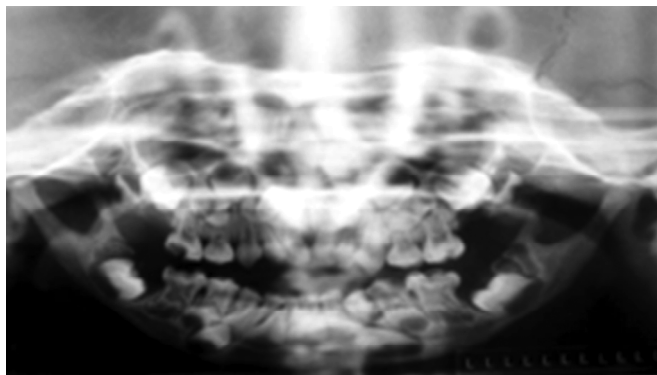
Panoramic radiography revealing obtuse mandible angle, acute caries and malpositioned teeth
